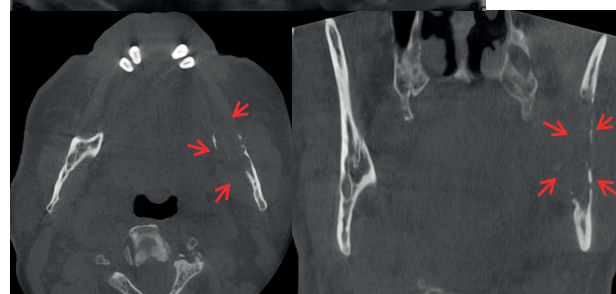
A) On panoramic radiography, irregular areas of cortical bone extending to the ramus in the left posterior edentulous region of the mandible. B) Moth-eaten osteolytic areas in cortical and trabecular structure involving the inferior alveolar canal in the ramus region of the left mandible on CBCT axial and sagittal images.
